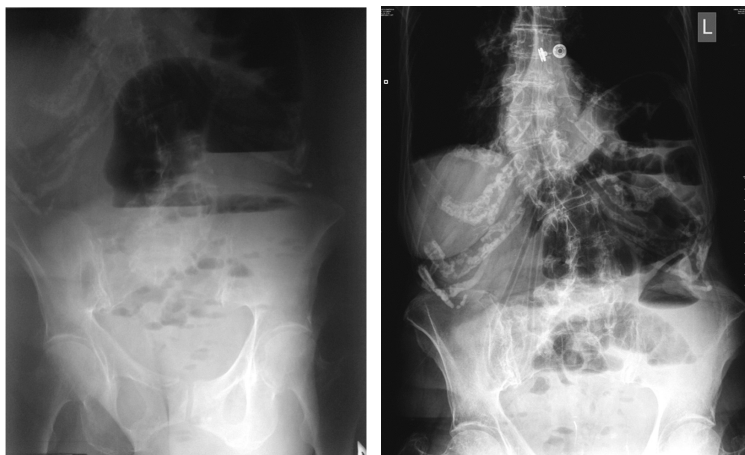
Plain abdominal radiographs in caecal volvulus
